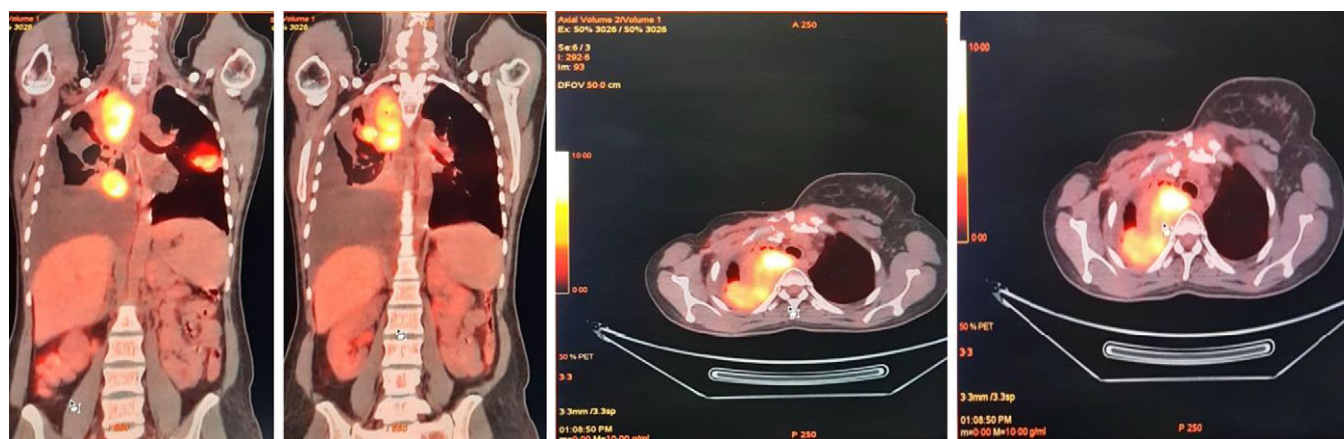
Multiple pleural-based soft-tissue mass lesions in the lungs, largest measuring 7.8 × 7.7 × 10.8 cm (SUV_{max} 11.35) in the superior segment of right lower lobe, infiltrating the mediastinum and indenting the trachea with architectural distortion of lung parenchyma on the right side.
